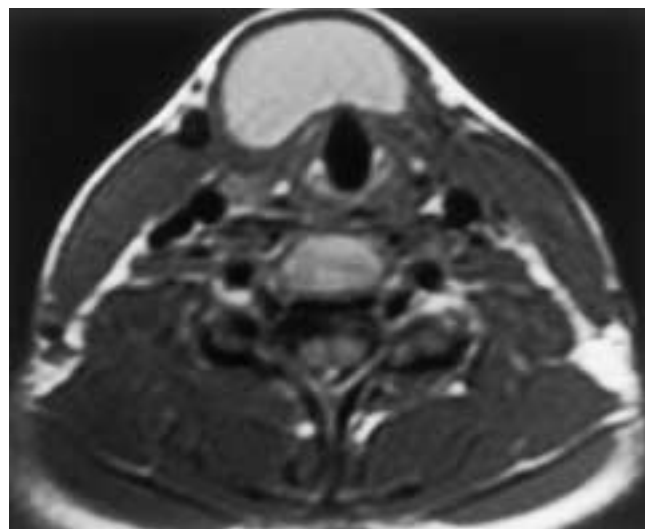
Thyroglossal duct cyst containing proteinaceous material. Unenhanced axial T1-weighted image shows a midline cyst that is hyperintense due to its proteinaceous contents.
